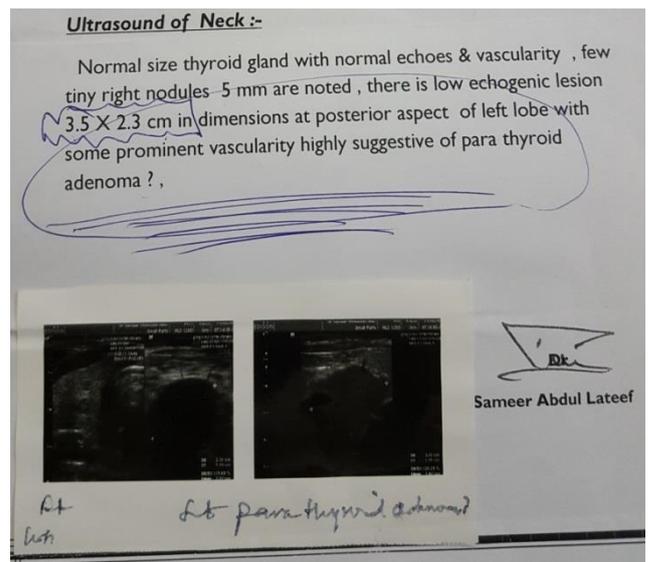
pre-operative localization by ultrasonography
